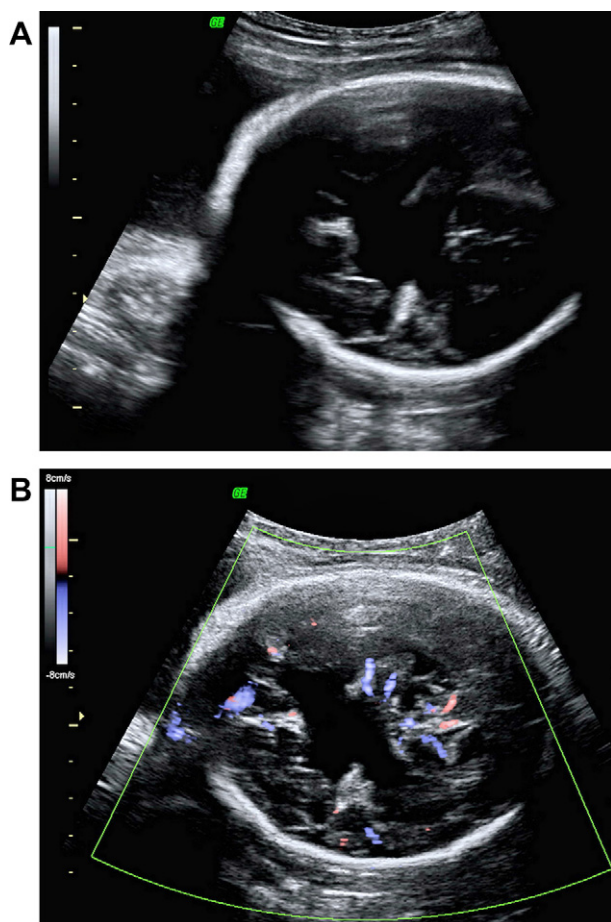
Fetal head ultrasound at 33 weeks gestation revealed irregular hypoechoic cerebral space-occupying lesion without blood flow. (A) Irregular hypoechoic cerebral space-occupying lesion revealed by two-dimensional US. (B) Cerebral space-occupying lesion without blood flow revealed by high-definition color Doppler US.
